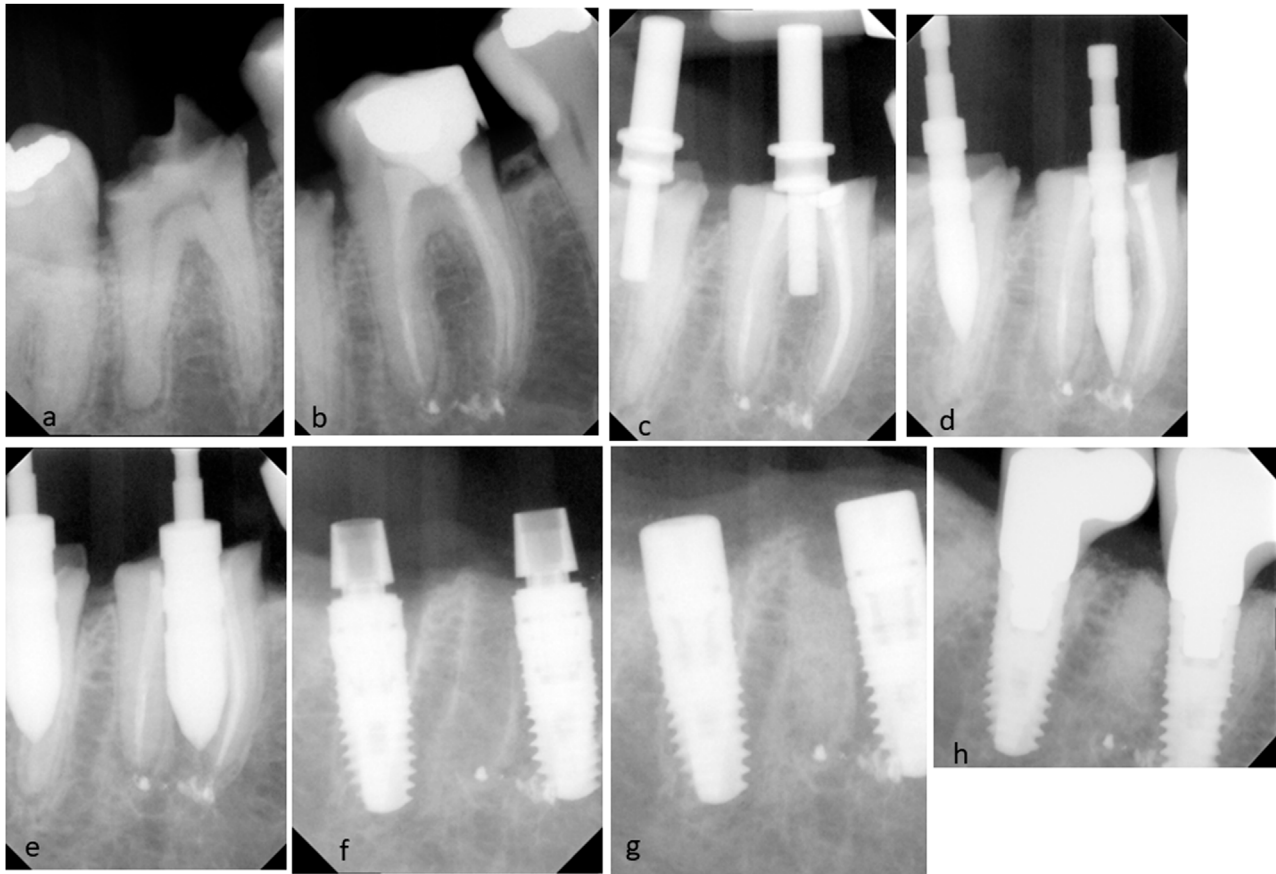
Radiographic images of the surgical procedure. (A,B) Preoperative radiographs of mandibular left first and second molars; (C) pre-extractive interradiacal implant bed preparation. The parallel pins inserted in the initial osteotomy directly through each molar's initially retained root complex of the left first and second molars; (D,E) other osteotomy drills drilled directly through the root complex; (F) insertion of cylindrical screw-type implants after removal of the remaining roots; (G) healing abutments were placed and bone graft material filled the extraction socket around each implant; and (H) a periapical radiograph taken 6 months after placement of the definitive restorations.
